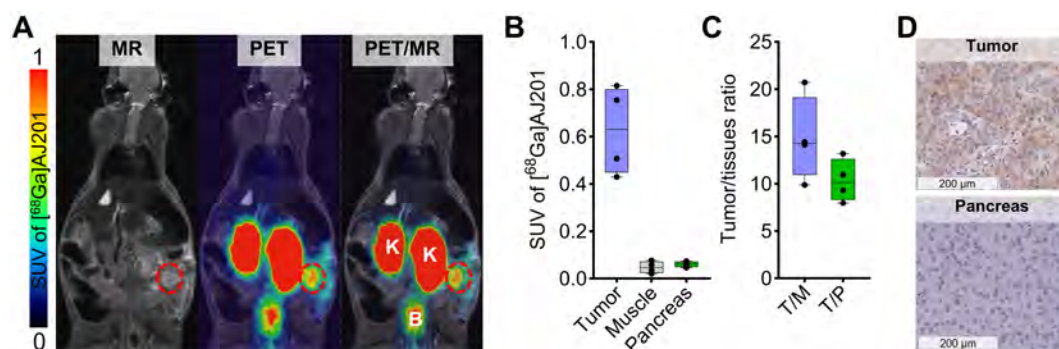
In vivo* distribution of [⁶⁸Ga]AJ201 in Panc1-orthotopic tumor model. A) Coronal sections of the fused PET/MR images showing [⁶⁸Ga]AJ201 distribution. Primary tumor is indicated by red circle; K = Kidney, B = Bladder. B) Quantification of accumulated activity in tumor, muscle and pancreas of images shown in panel A (n = 4-5) C) tumor-to-muscle (T/M) and tumor-to-pancreas (T/P) ratios from the images shown in panel A (n = 4) D) EphA2 IHC of orthotopic Panc1 tumor and normal pancreas to validate the EphA2 expression. Panc1 orthotopic tumor model was generated by surgically implanting a 3-5 mm³ section of Panc1 tumor xenograft directly onto the pancreas. The implanted tumors were allowed to grow for 10 days, after which they were ready for imaging. At this stage, MRI measurements indicated that tumor sizes ranged from 10-50 mm³. data in figure B and C is shown as box and whisker plots (median ± IQR) showing all data points (n = 3-5).
